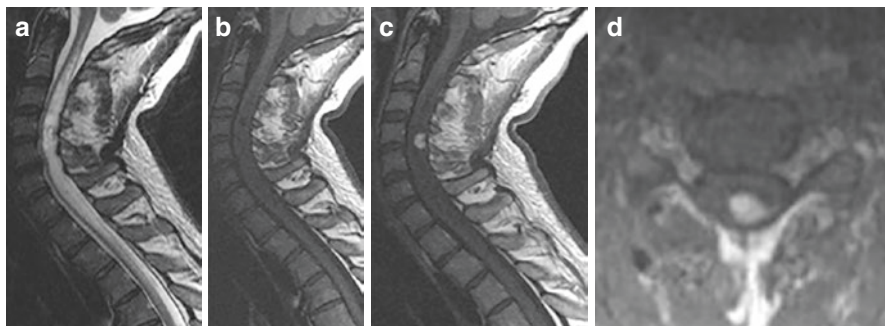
Hemangioblastoma. Sagittal T2-weighted (a), T1-weighted (b), and contrast enhanced T1-weighted (c, d) images demonstrating well defined and strongly enhancing small mass in dorsal cervical spinal cord at the C4–C5 level, associated with edema and syrinx
